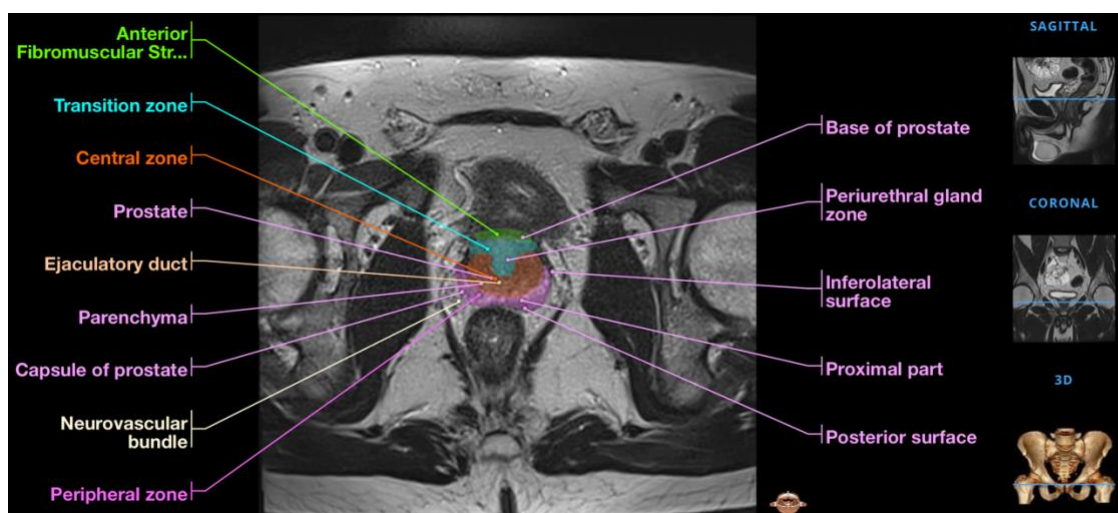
Axial T2-weighted magnetic resonance imaging (MRI) depicts a typical male pelvis at the prostate level. The image shows the prostate's zonal anatomy, which consists of central, peripheral, and transition zones, alongside the fibromuscular stroma. Obtained from (20)
